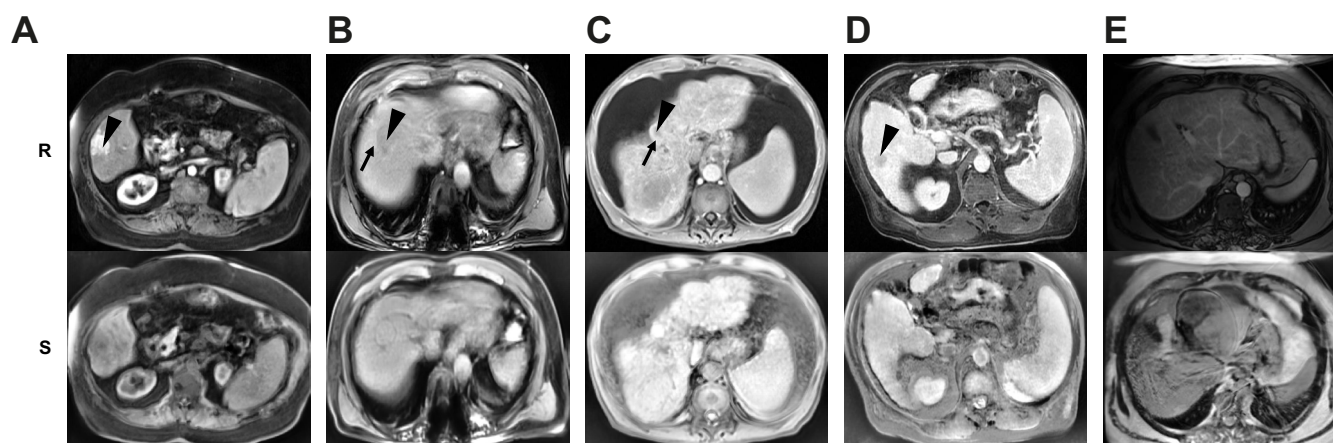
Cases of model failure in synthetic MRI. Examples are shown of model failure in synthetic MRI phases. (A–D) Instances where the model did not correctly reproduce HCC LI-RADS features present in ground-truth (real) (R) MRI phases in their corresponding synthetic (S) phases. LI-RADS features shown are (A) non-rim arterial hyperenhancement (arrowhead) on the arterial phase, (B,C) non-peripheral washout (arrowhead) and an enhancing capsule (arrow) surrounding the HCC lesion on the portal venous (B) and delayed (C) phases, and (D) hypointensity on the hepatobiliary phase. (E) Synthetic delayed MRI phase of a patient with cirrhosis with incorrect liver anatomy, undiagnosable cirrhosis, and more artifacts compared with its corresponding ground-truth phase. HCC, hepatocellular carcinoma; LI-RADS, Liver Imaging Reporting and Data System; MRI, magnetic resonance imaging.
